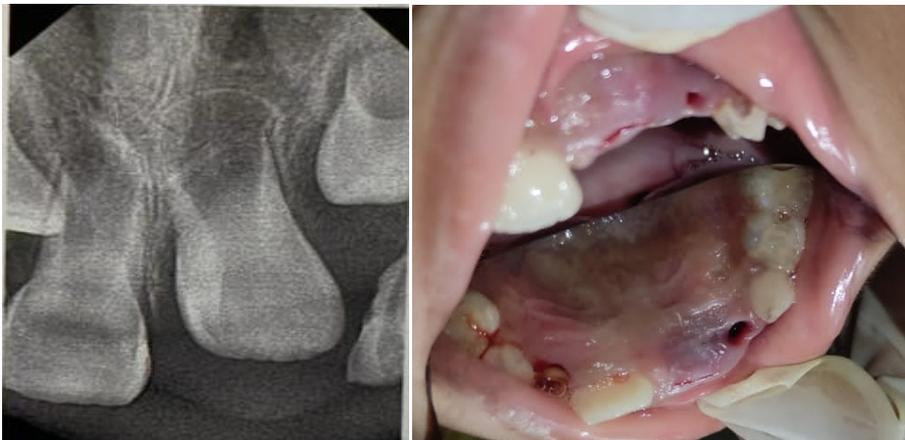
Radiographic feature. Figure 3 After surgical exposure.
